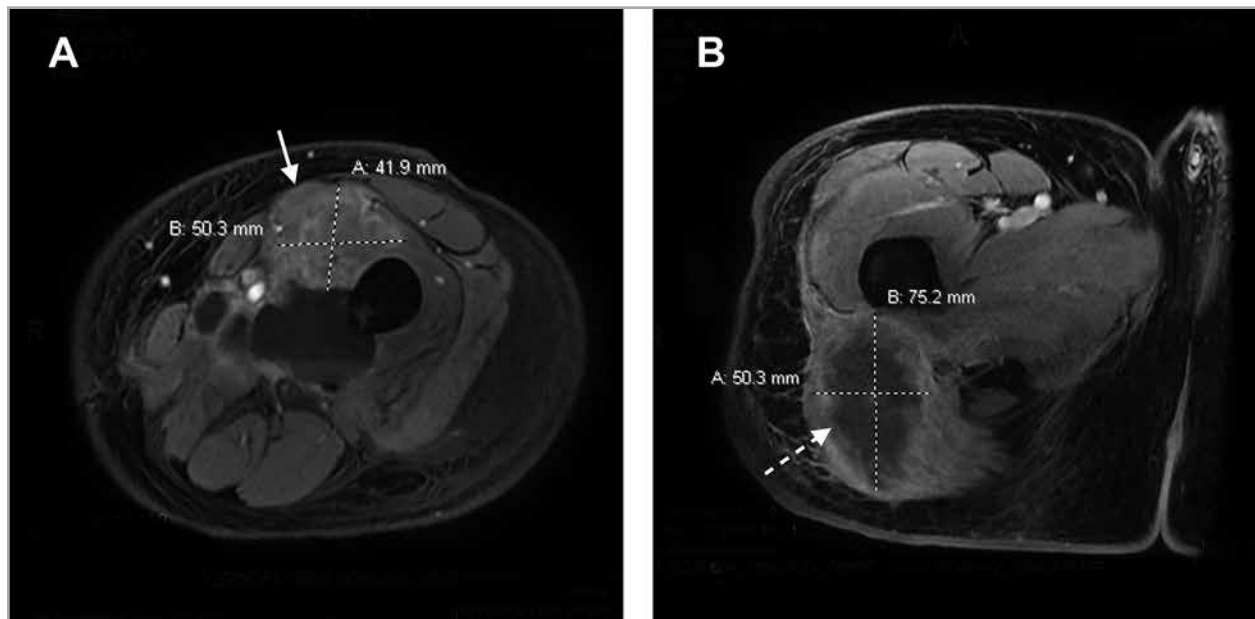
Magnetic resonance images of the (A) left thigh and (B) right hemi-pelvis demonstrate centrally necrotic masses consistent with advanced malignancy. The recurrent tumor in the left anterior vastus medialis muscle (arrow) measures 4.2 cm x 5.0 cm in cross section, while the metastasis in the right gluteus maximus muscle (dashed arrow) measures approximately 5.0 cm x 7.5 cm in cross section and extends at least 10.5 cm in length.
